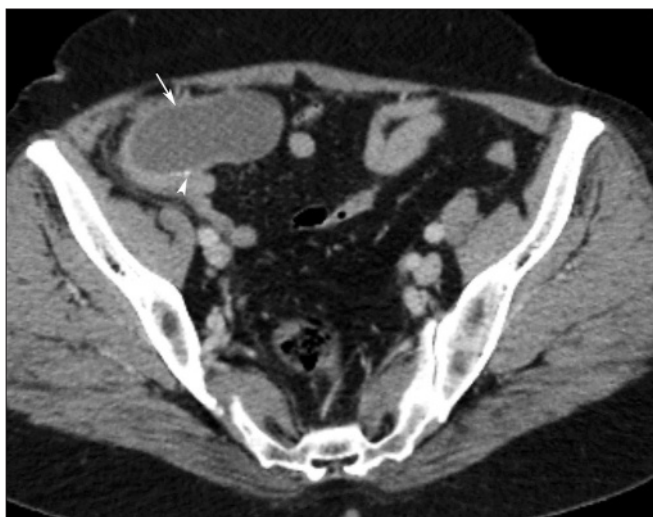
Contrast-enhanced (intravenous) axial CT scan of lower abdomen shows long tubular cystic mass with low-density content (arrow) with mural calcifications (arrowhead) on the right lower quadrant
